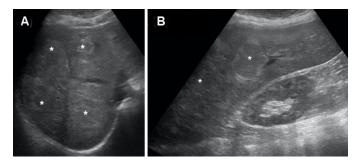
(A) Transverse and (B) longitudinal ultrasound images of the liver demonstrate hyperechoic lesions (*) scattered throughout the liver.
